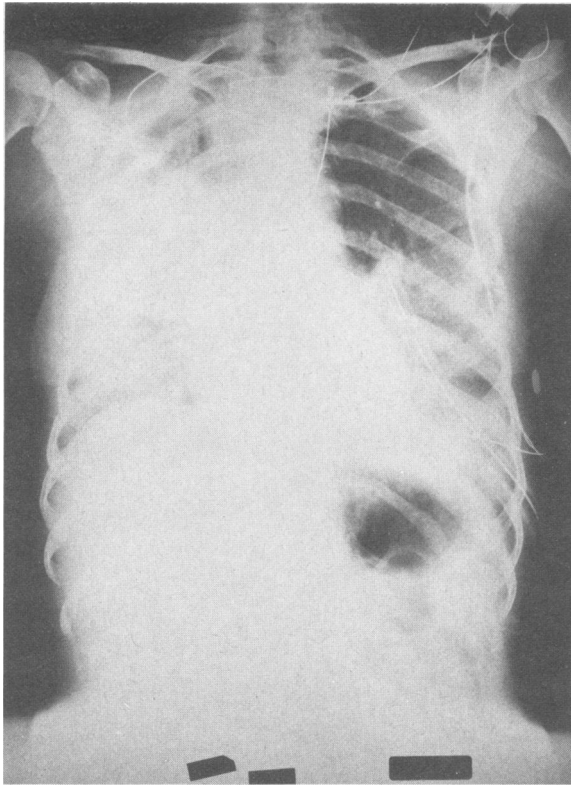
X-ray appearance of lung contusion in ARDS following automobile trauma in 34-year-old woman. Severe contusion of right lung is present.
